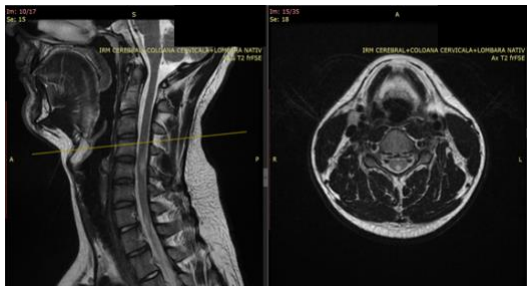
Second non-specific patient, former MRI. Multiple, medullary, demyelinating lesions of the cerebellum, brainstem and cervico-thoracic spinal cord. Source: Author's elaboration.
